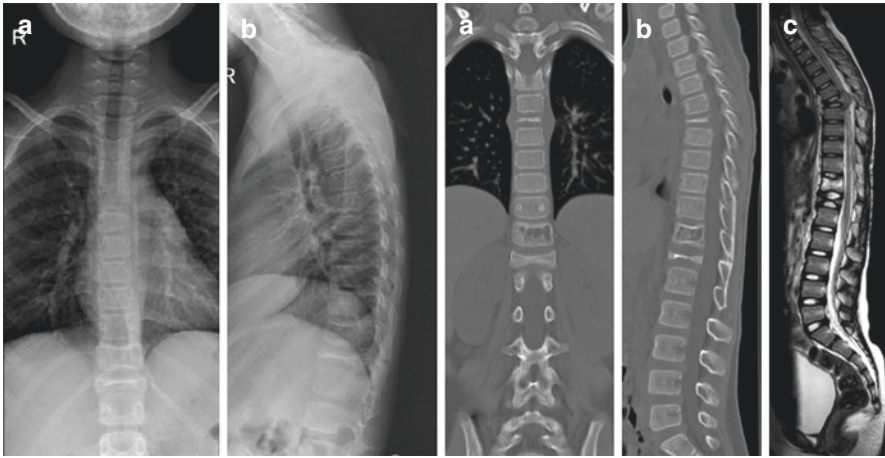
Eosinophilic granuloma (T12). Standard radiographs (a and b, left side), CT scan (a and b, right side), and MRI (c, right side)
